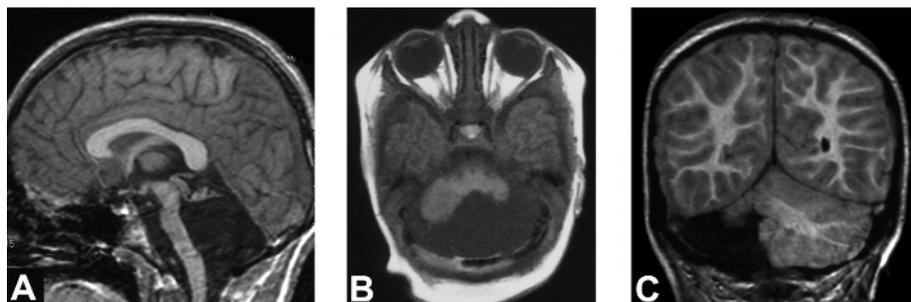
MRI of the cerebellum. (A) T1-weighted sagittal image of near complete cerebellar agenesis in case 12. (B) T1-weighted axial image in case 14 showing absence of the left cerebellar hemisphere and the right posterior cerebellum. (C) SPGR coronal image in case 15, which shows near complete agenesis of the right cerebellum.
